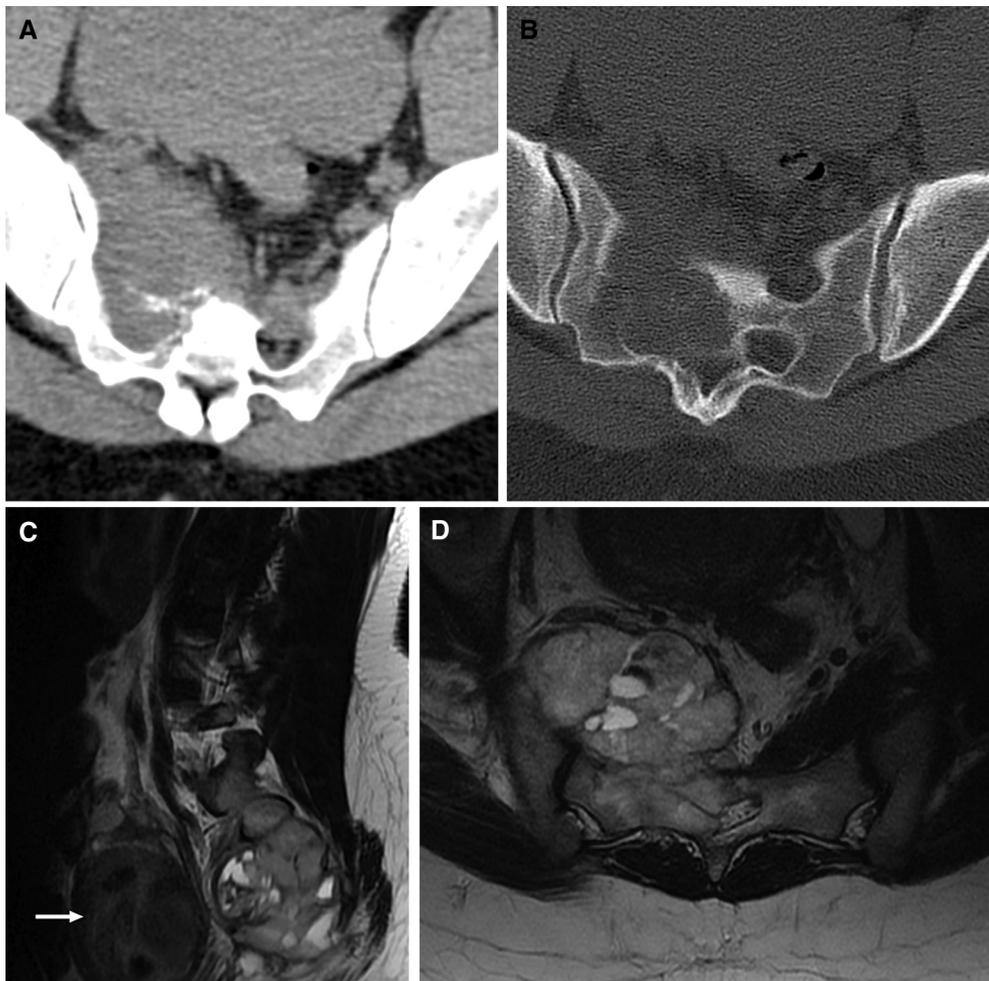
Sacral metastasis. Axial computed tomography in (A) soft tissue and (B) bone windows in a patient with known uterine sarcoma demonstrates a destructive soft tissue mass centred in the right sacral ala consistent with a metastatic lesion. (C) Sagittal and (D) axial T2-weighted magnetic resonance imaging of the lumbosacral junction confirms a large multilobulated solid and cystic mass arising from the sacrum with enlargement of the uterine fundus (white arrow) consistent with the known primary tumour.
